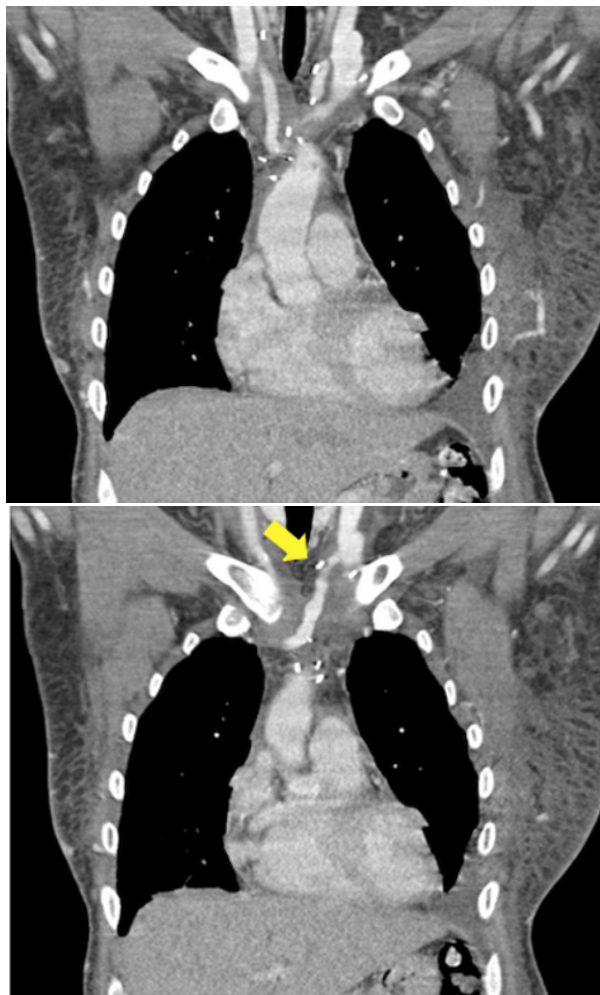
One-year follow-up venous computed tomography angiography images demonstrating complete patency of the right jugular-cava confluent and a 20% reduction in the patency of the left branch shunt (arrow).
